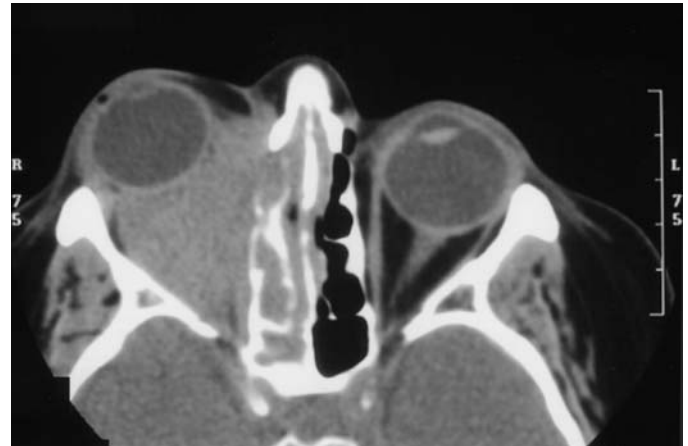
FIGURE e28-5 Computed tomography of the orbits in a patient with Wegener's granulomatosis who presented with right eye proptosis. The image demonstrates inflammatory tissue extending from the ethmoid sinus through the lamina papyracea and filling the orbital space.
